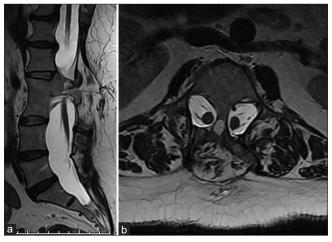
Magnetic resonance imaging of the lumbar spine T2weighted sequence demonstrating the type I split cord malformation (a: Sagittal view; b: Axial view).
